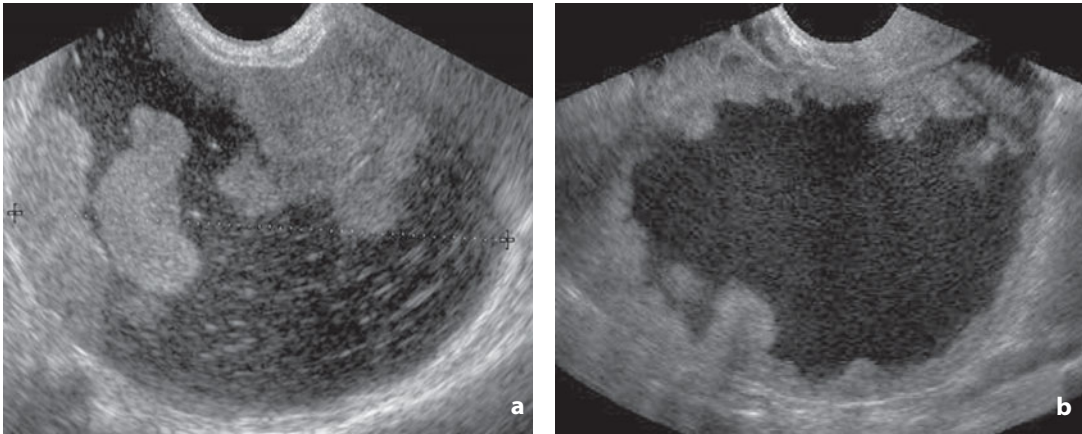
Transvaginal ultrasonography. Serous adenocarcinoma. a Large cystic lesion with thin walls containing corpuscular blood material and large solid components. b Different mass with cystic appearance and mildly thicker walls displays multiple solid mural components within the lumen
